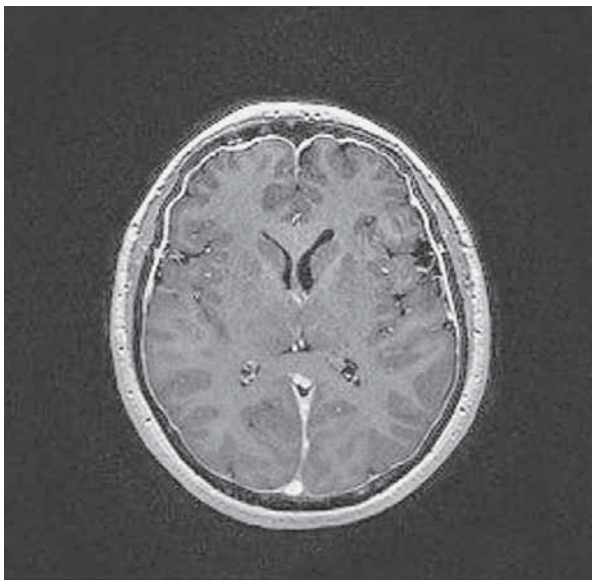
Axial contrast enhanced T1-weighted MRI shows diffuse bilateral meningeal enhancement.
